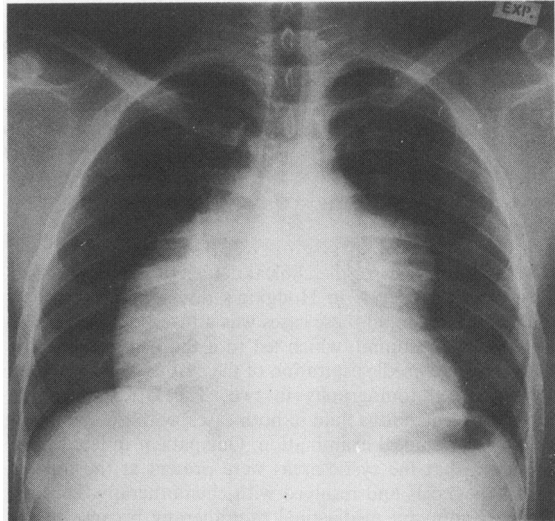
Chest radiograph showing mediastinal mass.
